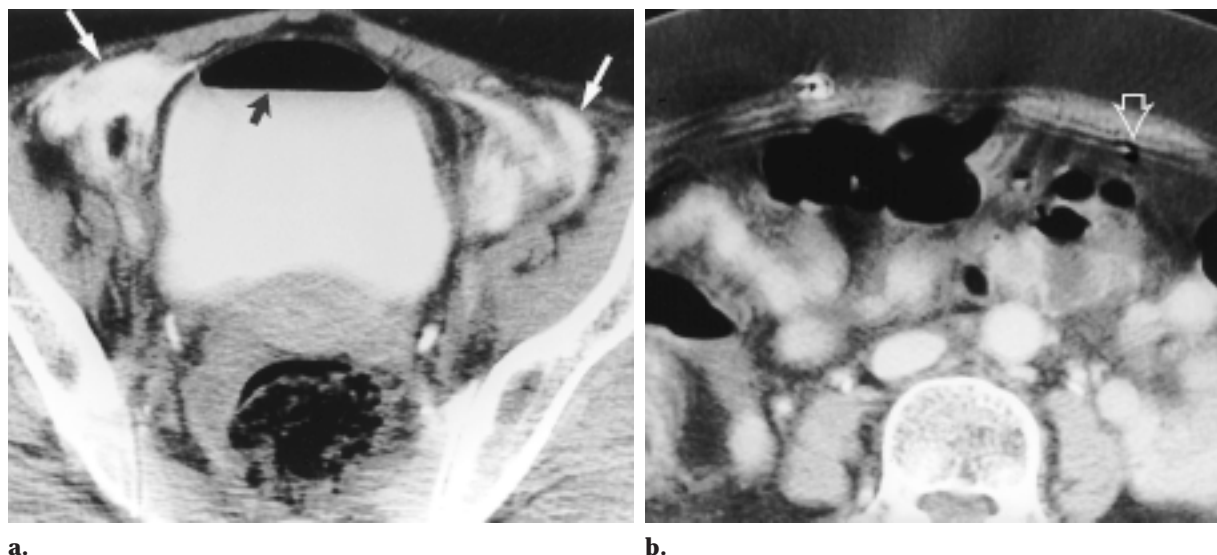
Extraperitoneal bladder rupture and normal bowel loops in a 77-year-old woman. (a) CT cystogram obtained after retrograde filling of the bladder shows an intravesicle air-contrast level (black arrow) and contrast material in the perivesicle extraperitoneal space (white arrows). (b) On a CT image obtained at a higher level, abdominal wall motion artifact blurs the outline of a small focus of air in the preperitoneal space (arrow). The air was introduced during retrograde bladder filling and mimics free intraperitoneal air.
